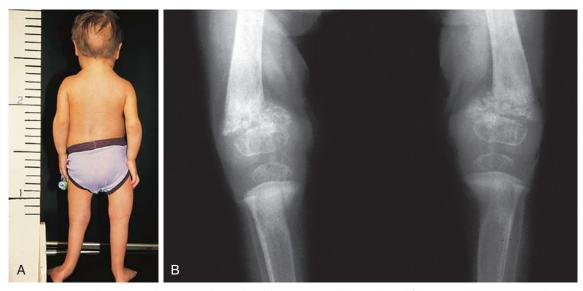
Autonomous hyperparathyroidism and severe renal osteodystrophy in a 6-year-old boy with renal failure caused by posterior urethral valves. A, Bossing of the occiput. B, Radiograph shows distal femoral and proximal tibial areas, as well as subperiosteal erosion of the cortical bone and active rickets in the epiphyseal ossification centers.
